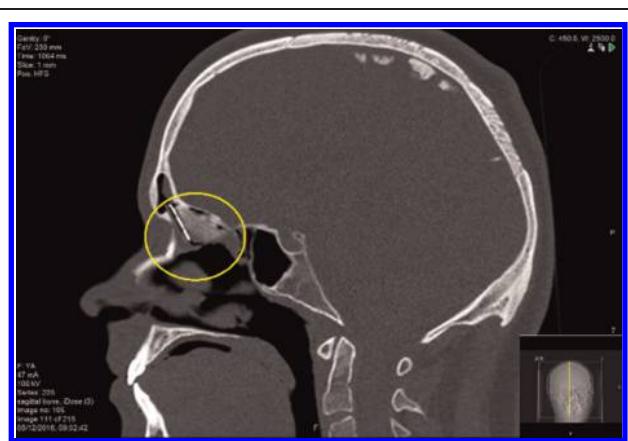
Postoperative sagittal computed tomography at 3 months with frontal sinus stent in situ.
